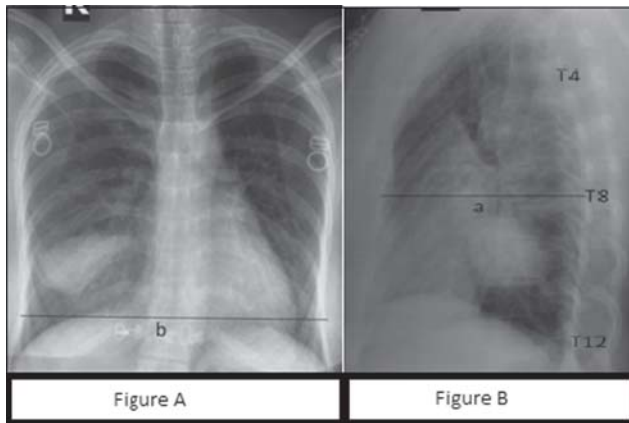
(A&B). Chest radiograph (A) (postero-anterior view) showing a well-defined lobulated homogeneous opacity in the right lower zone and (B) (lateral view) showing decreased distance measured from T8 thoracic vertebra to line joining the T4 and T12 vertebra.
